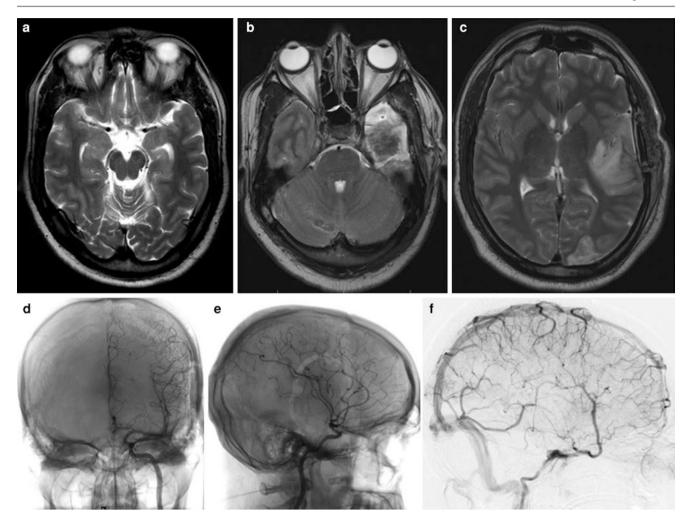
In a 41-year-old man with complex partial seizures, preoperative magnetic resonance imaging (MRI) showed volume reduction of the left temporal lobe with hippocampal atrophy suggestive of mesial temporal sclerosis (a). Anterior temporal lobectomy with amygdalohippocampectomy was done, but, during the early postoperative period, the patient demonstrated a gradual decline of his consciousness level and development of right-side hemiparesis. Postoperative MRI (b, c)
